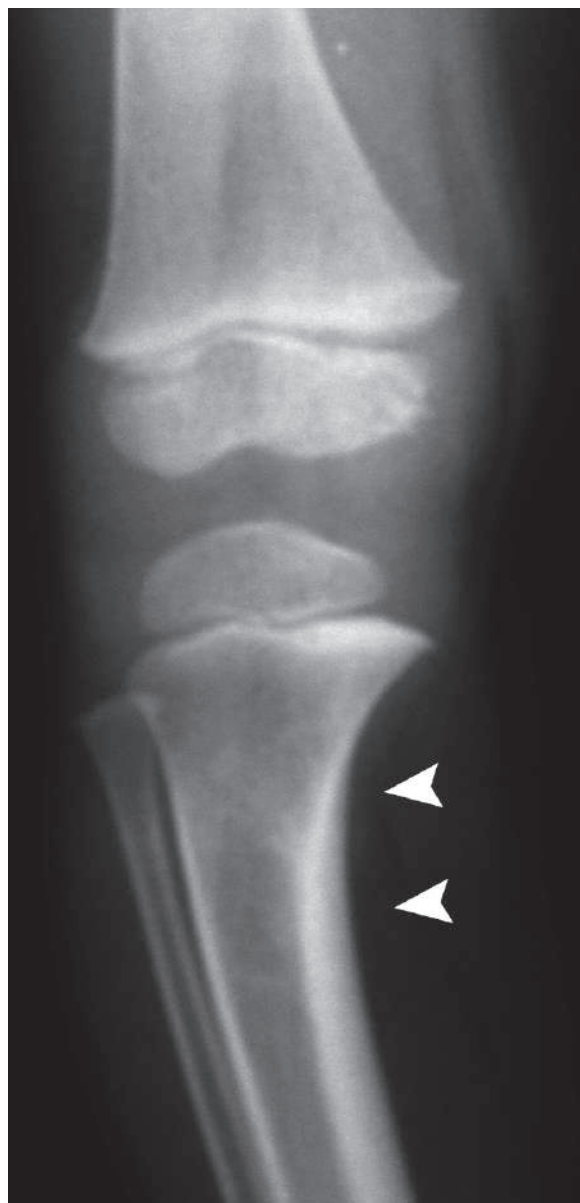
Anteroposterior plain radiograph of the right knee in a child with rickets shows mild bowing of the proximal tibial metaphysis (*arrowheads*)
